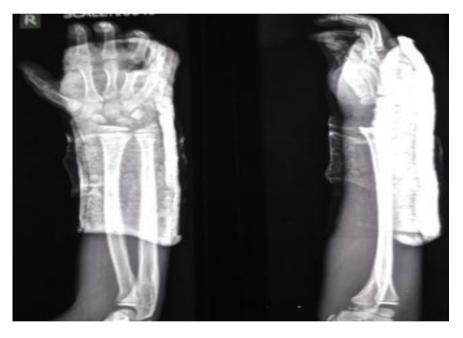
Post reduction X-ray right wrist
